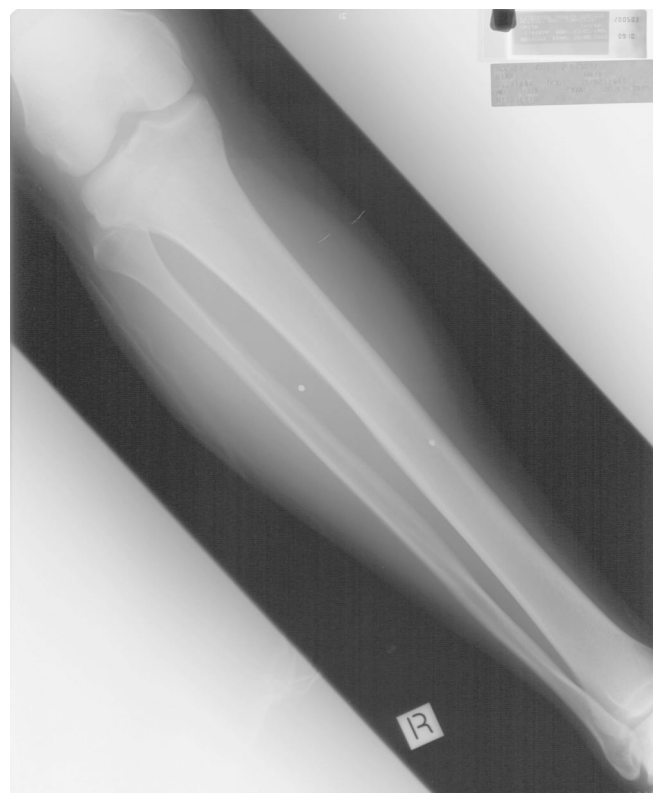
Pellet emboli visible on X-ray film of the right leg (anteroposterior view).
